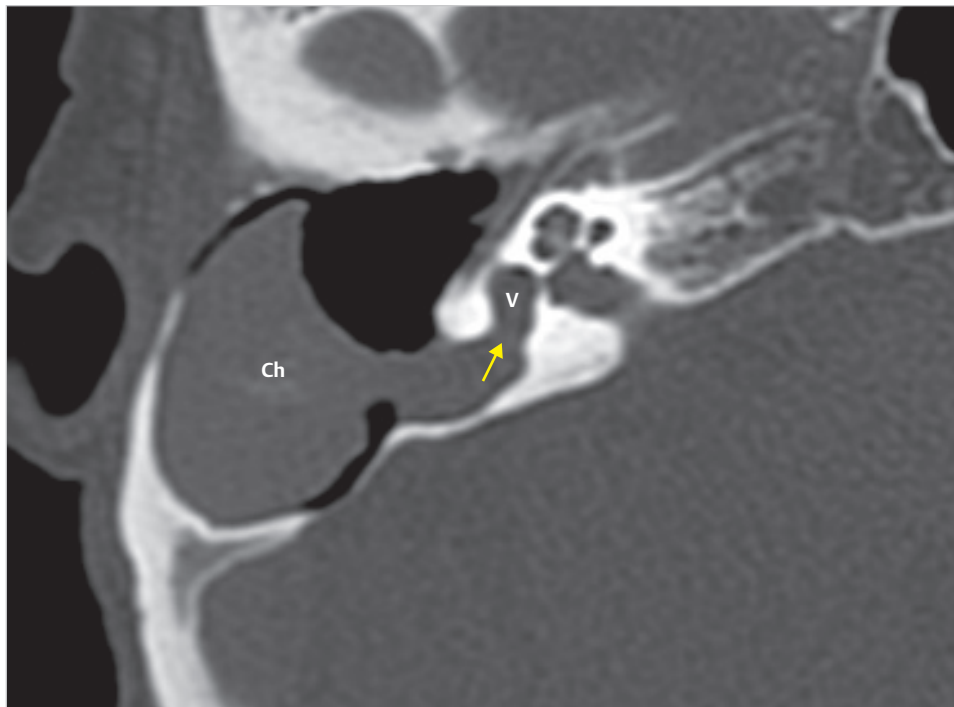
The patient underwent middle ear surgery in childhood. Immediate hearing loss followed the surgery, and the patient has never been followed up for tens of years. Hearing examination revealed unmeasurable bone conduction. The preoperative CT shows formation of huge cholesteatoma eroding not only semicircular canals but also the vestibule (*arrow*). Ch, cholesteatoma; V, vestibule.
